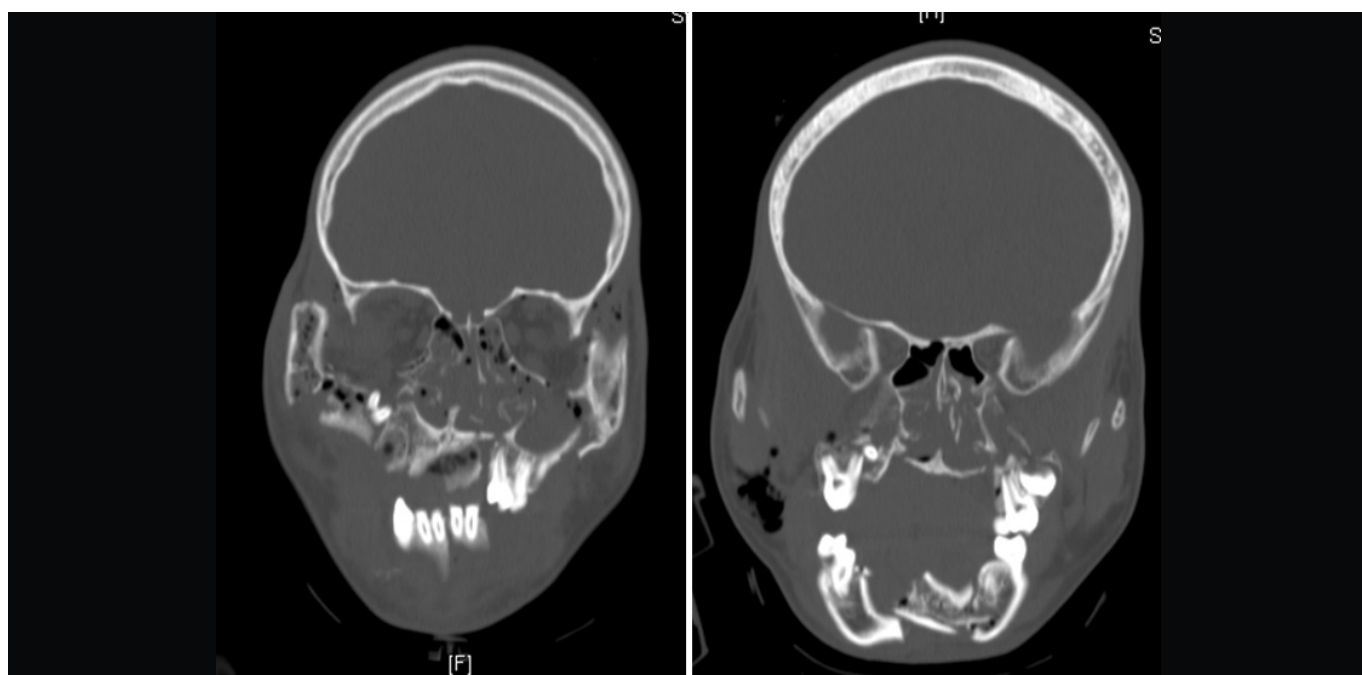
CT images skull performed
